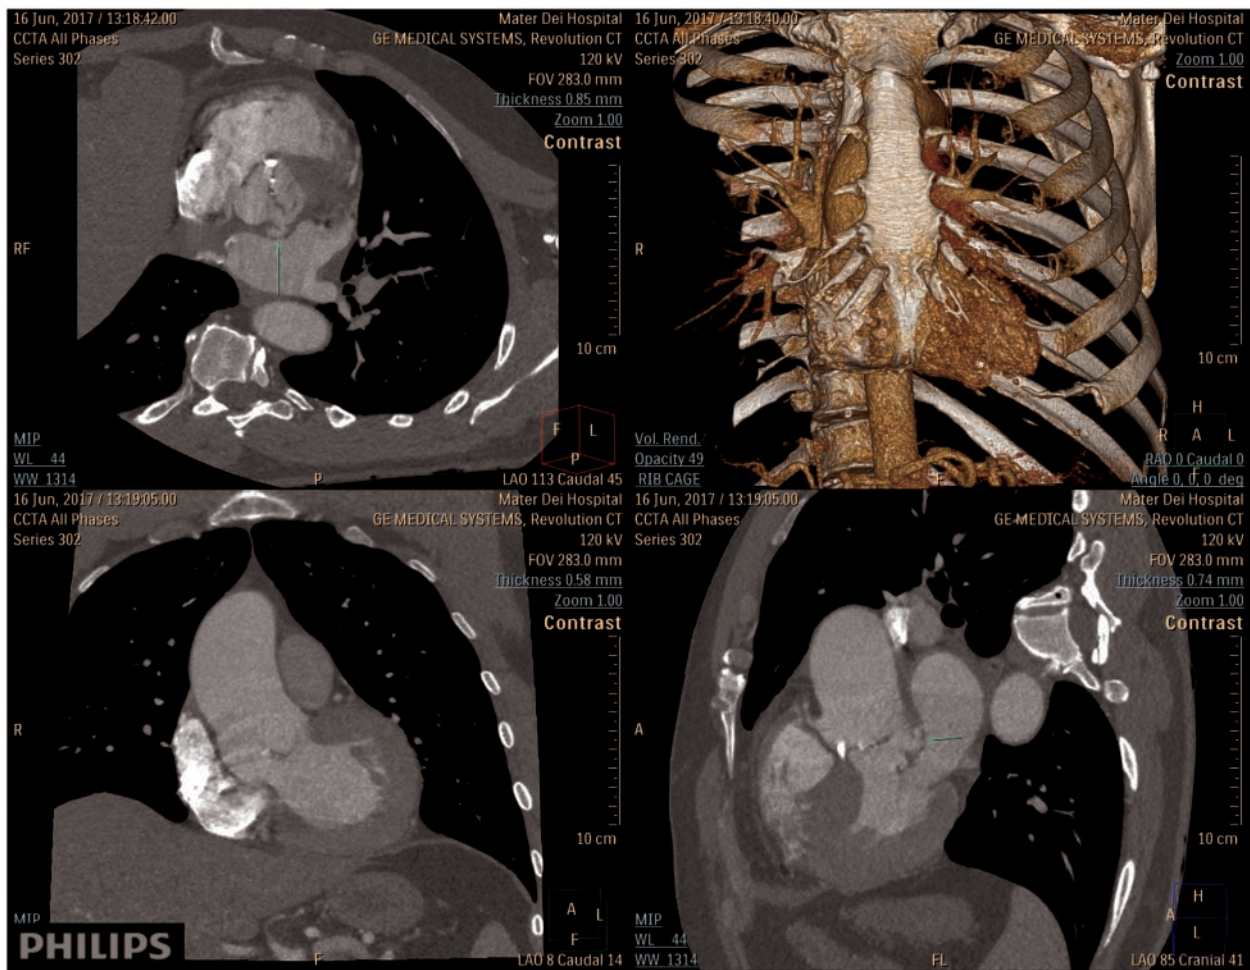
Cardiac computed tomography showing the aortic root abscess.
